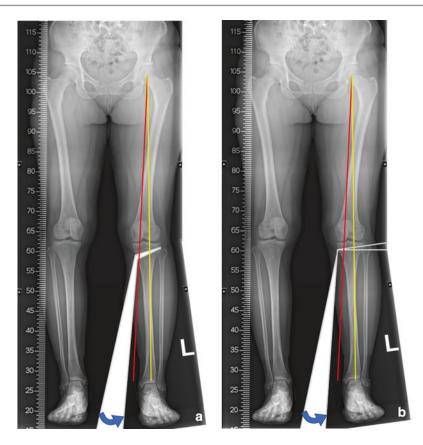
Graphic depiction of alternate method used to calculate the correction angle of a high tibial osteotomy using a full-length anteroposterior roentgenograph of the lower extremity. The roentgenograph is cut (see text) to allow the center of the femoral head (CFH), the 62% coordinate, and the center of the tibiotalar joint (CTTJ) to become colinear. The angle of the resulting wedge of roentgenograph overlap equals the desired angle of correction. a Medial open wedge osteotomy, b Lateral close wedge osteotomy
